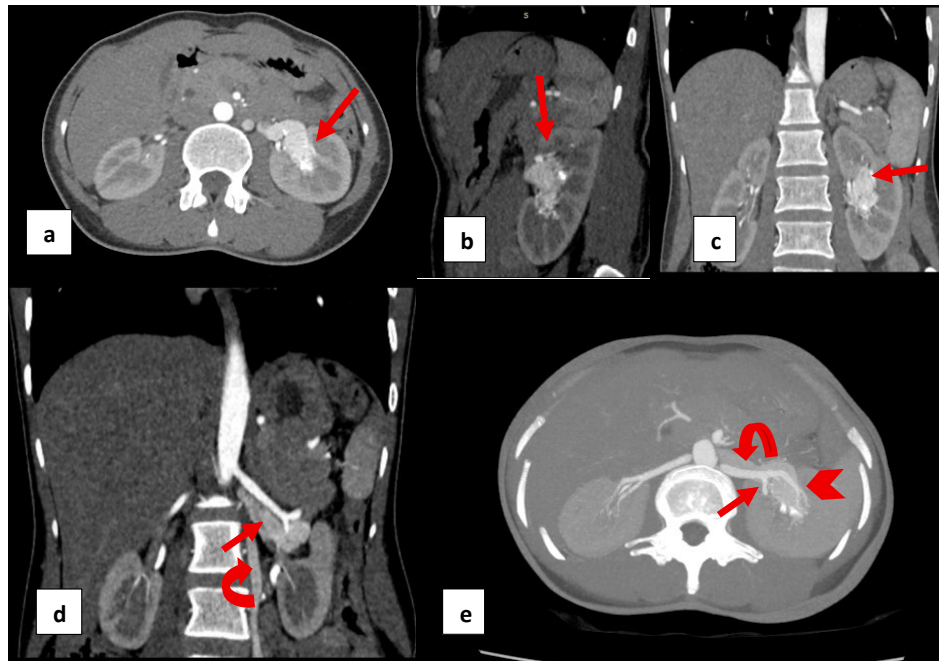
(a) Axial, (b) sagittal and (c) coronal arterial phase CT images showing AVM (arrow) involving the left kidney with dilated and opacified left renal vein. d) Coronal image showing opacified left renal vein in arterial phase with dilated and opacified left gonadal vein (curved arrow) non opacified right renal vein. e) Axial MIP images showing left renal artery (arrow) with AVM (arrow head) involving the left kidney with a nidus and opacified left renal vein (curved arrow) in arterial phase.
